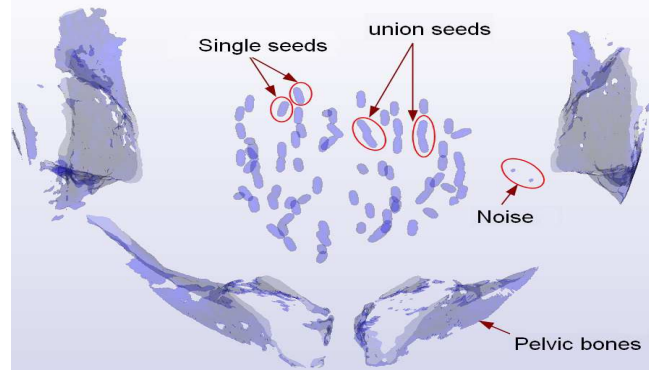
Example of connected component detection in a 3D CT image with 190 objects detected using an intensity threshold of 700 (16-bit gray-level intensity).
